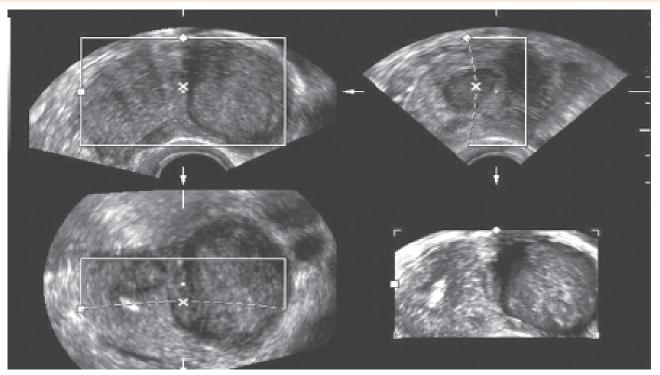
Three-dimensional ultrasound image of a subserosal uterine fibroid
